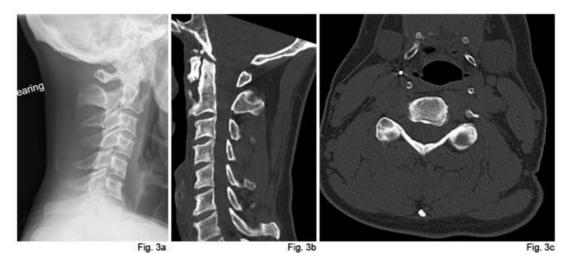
(1.5 column fitting): Post-operative imaging demonstrating resolution of osteophytosis in a) lateral radiograph b) sagittal CT and c) transverse CT imaging.
